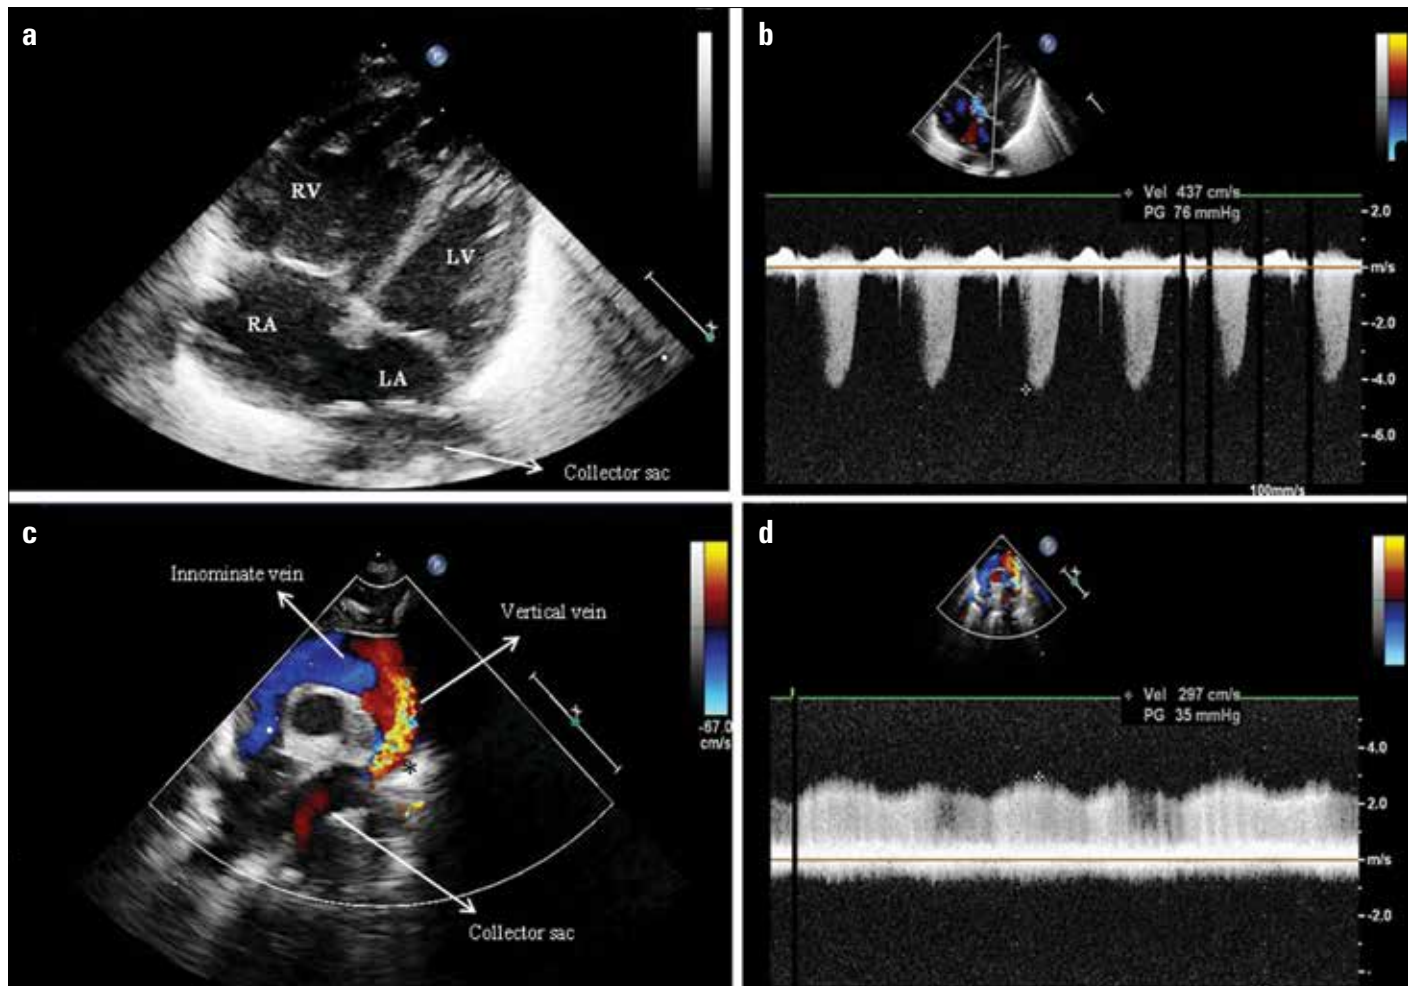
a-d. Echocardiographic views. (a) Four-chamber view, with emphasis on right ventricular enlargement. (b) Continuous wave Doppler of the tricuspid regurgitation. (c) Colour Doppler view of the vertical vein, with emphasis on the narrowed part. (d) Continuous wave Doppler of the narrowed part of the vertical vein
